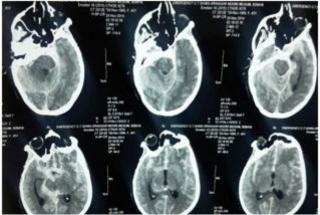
CT imaging showing subarachnoid hemorrhage.
